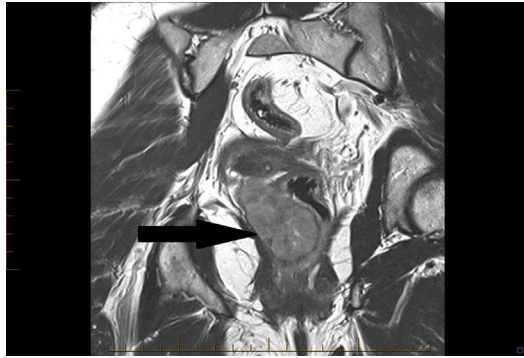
MRI coronal T2-weighted: primary anorectal GIST (arrow).
